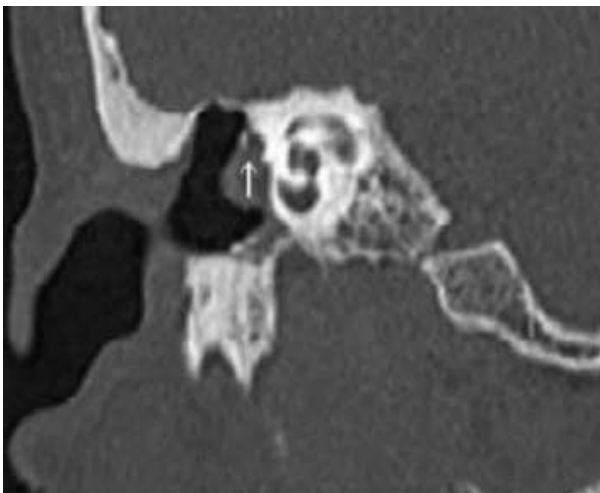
Axial CT scan of the right petrous bone showing erosion of the facial nerve canal (arrow) at its second (tympanic) segment, related to soft-tissue opacification suggestive of a cholesteatoma
